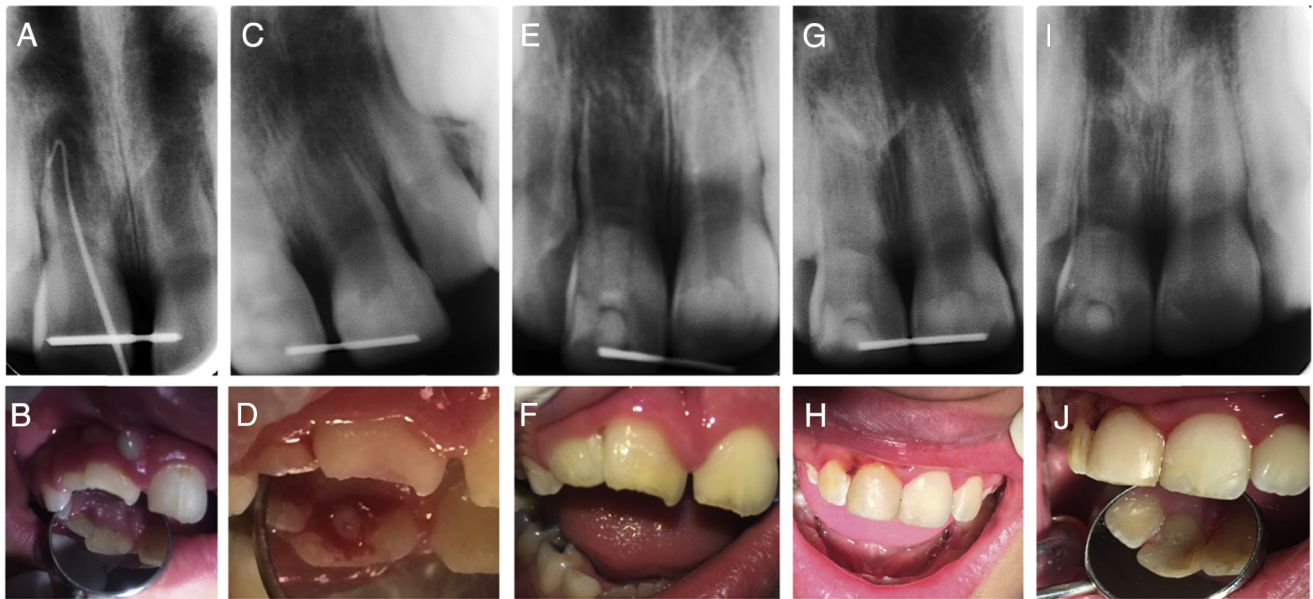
(A and B) A 7-year-old boy with immature necrotic tooth with chronic apical abscess of the right maxillary central incisors. Intraoral examinations showed a sinus tract and diffuse swelling and pus discharge through the labial sinus. (C and D) Pus discharge after access cavity preparation. (E and F) Radiographs after 6 months showed complete eruption of the tooth, and it was level with the adjacent teeth; there were signs of continued development of the apex. (G) At the 9-month recall, apical closure was observed. (I) The 18-month follow-up radiograph showed further apical closure and near complete apex development. (H and J) The 18-month follow-up showed minimal signs of discoloration.
